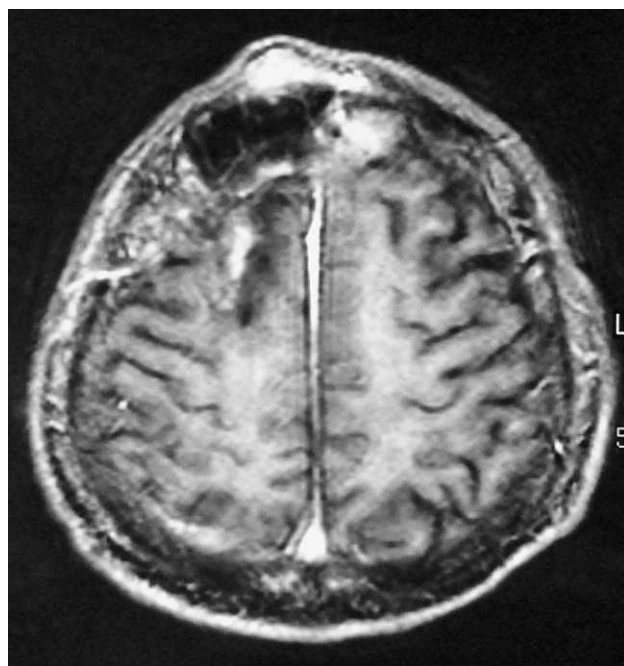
Head MRI showing a tumor located near the surgical site in the head.
